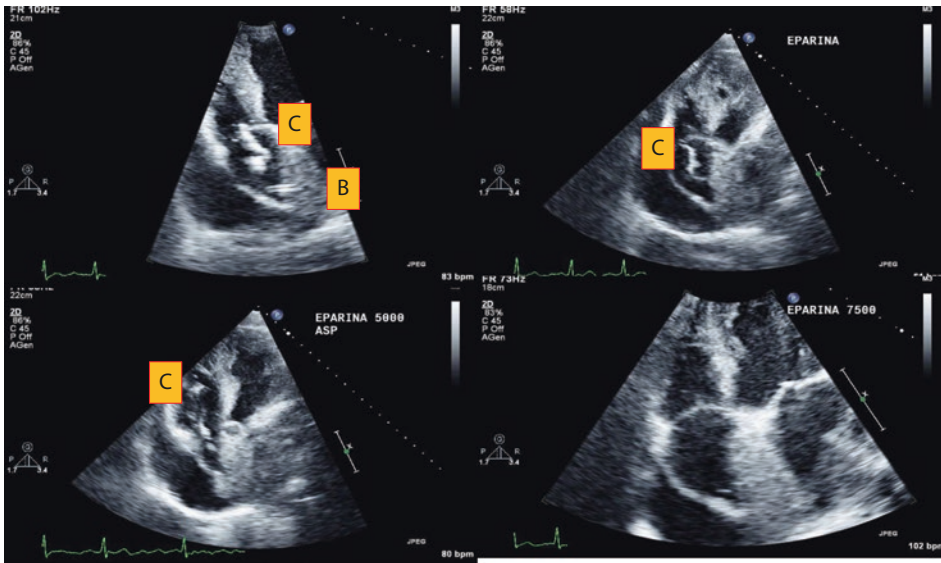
Bi-atrial mass (angiosarcoma). Transthoracic echocardiography during biopsy. A very mobile clot c related to bioptome b damage is promptly detected and treated with unfractionated heparin (EPARINA) and thrombus aspiration (ASP). In the *right-lower panel* clot is not recognizable
